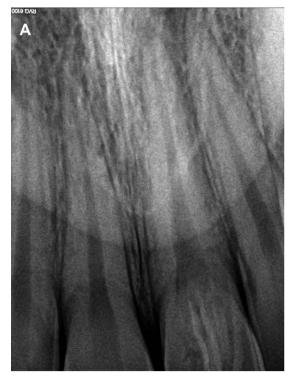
(A and B) Intraoral periapical radiographical examination of dens evaginatus on tooth 2.1
